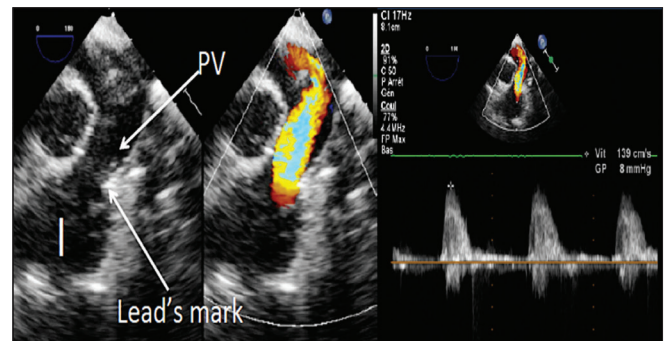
Intraoperative transesophageal echocardiogram short-axis view: the infundibular stenosis has disappeared after replacement of the epicardial leads. PV: Pulmonary valve
